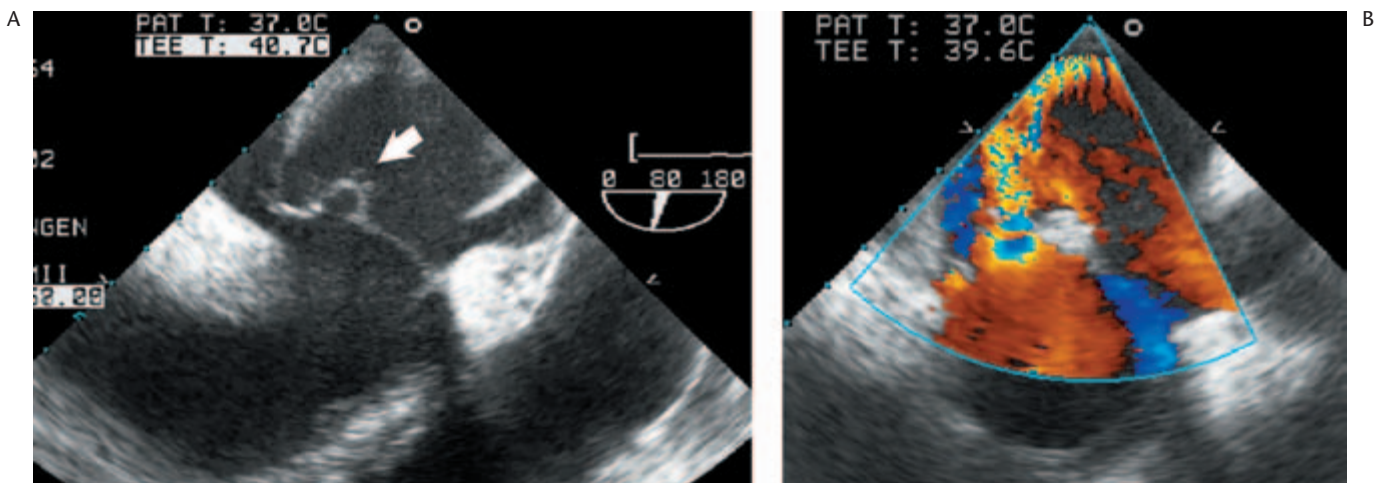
(A) Carpentier-Edwards bioprosthesis in the aortic position (transoesophageal short-axis view). Perivalvular aortic wall thickening is visible (arrows), indicating endocarditic tissue invasion. For comparison: (B), normal aspect of an aortic Carpentier-Edwards bioprosthesis.
